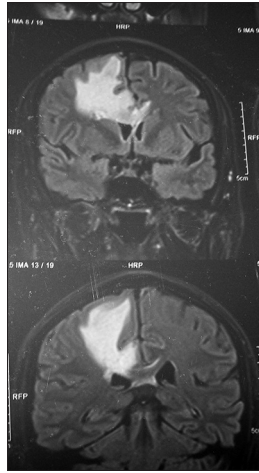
Magnetic resonance imaging brain before radiation therapy showing a mass lesion on T1-weighted image in the body of corpus callosum and right parafalcine gyrus with perilesional edema in the right fronto-parietal lobe
